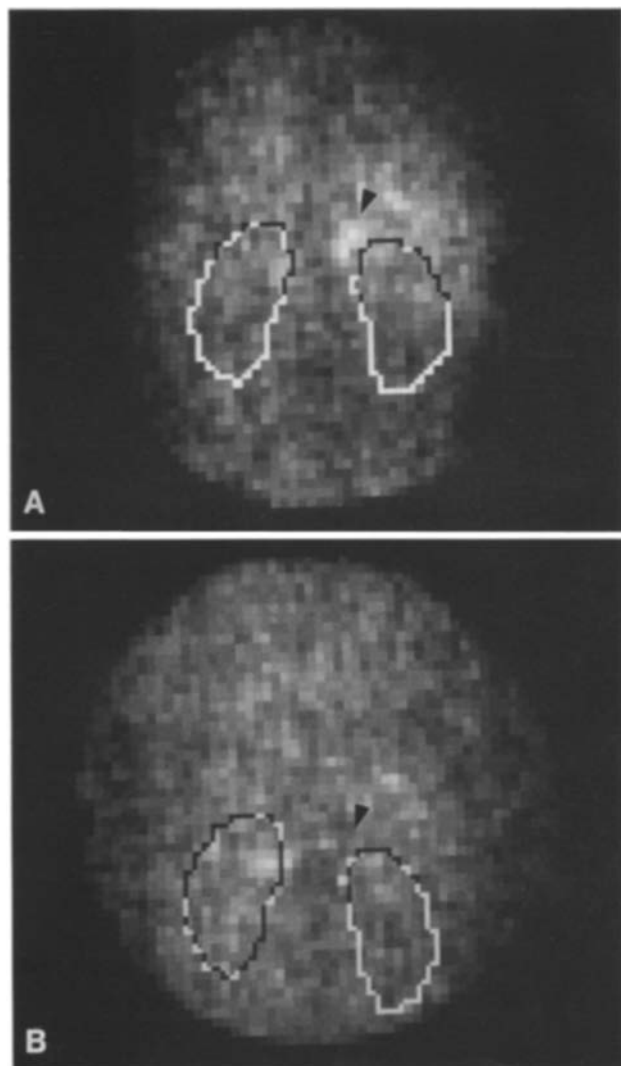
^{131}I -MIBG scintigrams in a 5-year-old child with a right adrenal neuroblastoma. Posterior views of the abdomen. A ^{131}I -MIBG scan following chemotherapy shows a small area of uptake due to a residual tumor in the right adrenal (*arrow*). B ^{131}I -MIBG scan performed after the complete surgical removal of the residual tumor (*arrow* indicates the site from which the tumor was removed) shows no uptake in the region
